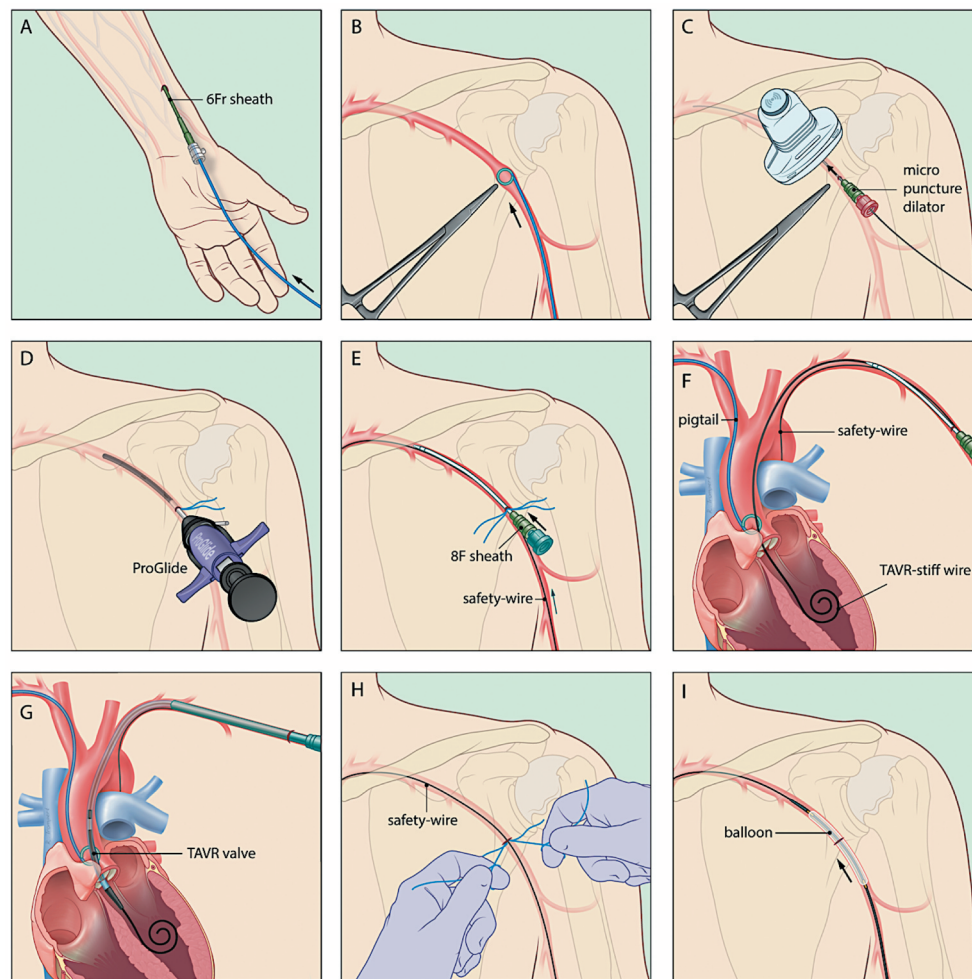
Percutaneous transaxillary TAVR – step-by-step description. (A) Placement of a 6 Fr sheath by the left radial artery, followed by insertion of a pigtail catheter. (B) The TAVR access site at the axillary artery is just medial of the caput humerus. A forceps and/or pigtail catheter can be used as fluoroscopic references. (C) The axillary artery is punctured under ultrasound and fluoroscopic guidance with the Micropuncture® access kit (Cook Medical, USA). (D) Axillary vessel pre-closure was secured by means of two ProGlides® (Abbott, USA). (E) Following the ProGlide deployment, a 8 Fr sheath is inserted and a Platinum Plus™ (Boston Scientific, USA) safety wire is introduced from the left radial access – this safety wire is typically introduced further to the descending aorta. (F) The aortic valve is crossed and a TAVR safety wire is introduced into the left ventricle. A pigtail for contrast injection into the aortic root can be introduced by the right radial artery or a femoral artery – the latter in case of use of a Sentinel cerebral protection system (Boston Scientific, USA) using the right radial artery. (G) Next, the large-bore TAVR introduction sheath is inserted by the axillary access – typically only for the straight part of the subclavian artery – and TAVR is performed. (H) Finally, the TAVR system is removed and the stiff wire is exchanged for a 0.035" J-wire. Following removal of the introducer sheath, the access site is closed by use of the ProGlides and, in most of the cases, an additional 6 Fr AngioSeal® (Abbott, USA) device. (I) In case of incomplete vascular closure, retrograde delivery of a PTA balloon or a sheathless 8 mm COVERA® vascular stent graft (Bard, USA) over the safety wire is possible.
